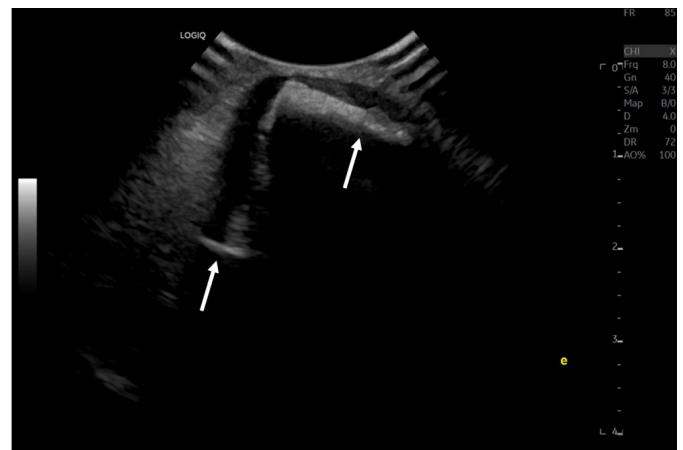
Ultrasound of the left shoulder, showing the ossified humeral diaphysis in a more anterior and apparently proximal location (right arrow), with posterior positioning of the humeral head (left arrow).
